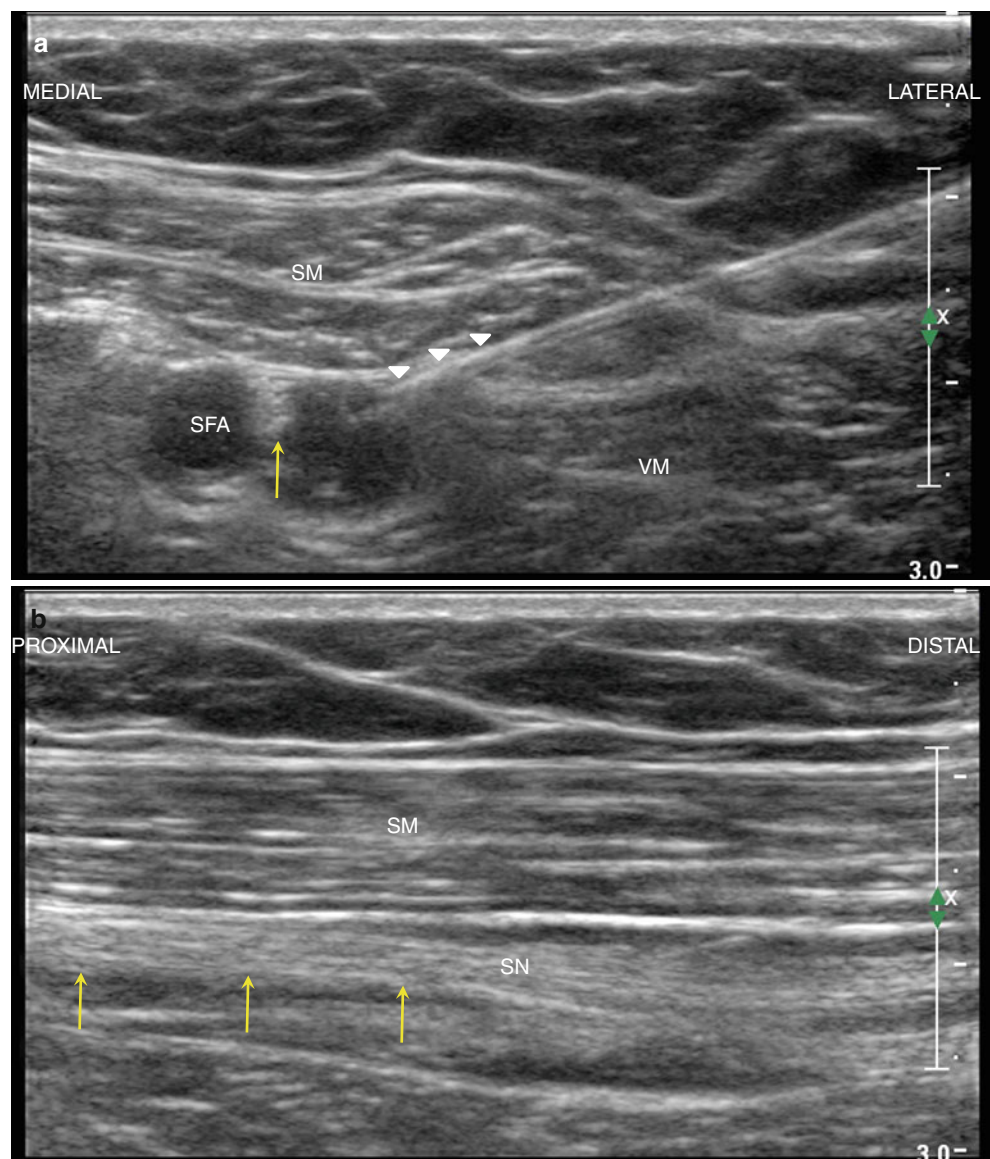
Serial sonograms demonstrating in-plane approach to adductor canal block deep to the sartorius muscle (SM). Panel (a) needle tip in plane for block injection (white arrowheads). Panel (b) long-axis view of the saphenous nerve (SN, long yellow arrows) after injection demonstrating local anesthetic tracking along the nerve course in the thigh
